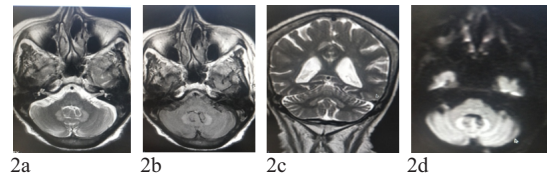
Signal change in the bilateral dentate nucleus. Axial T2W MR image (Fig 2a) and T2W FLAIR image (Fig 2b) and Coronal T2W image (Fig 2c) shows hyperintensity in dentate nuclei which shows restriction on DW image (Fig 2d)
